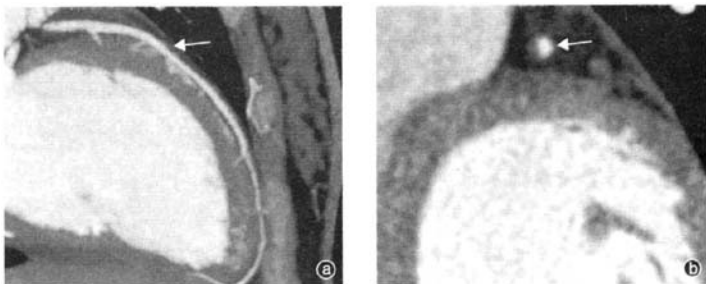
2010 年 1 月 15 日 26 岁女性急性心肌梗死患者冠状动脉多排螺旋 CT 横断面(a)与纵断面(b)检查示冠状动脉左前降支(箭头所示)近端斑块形成
